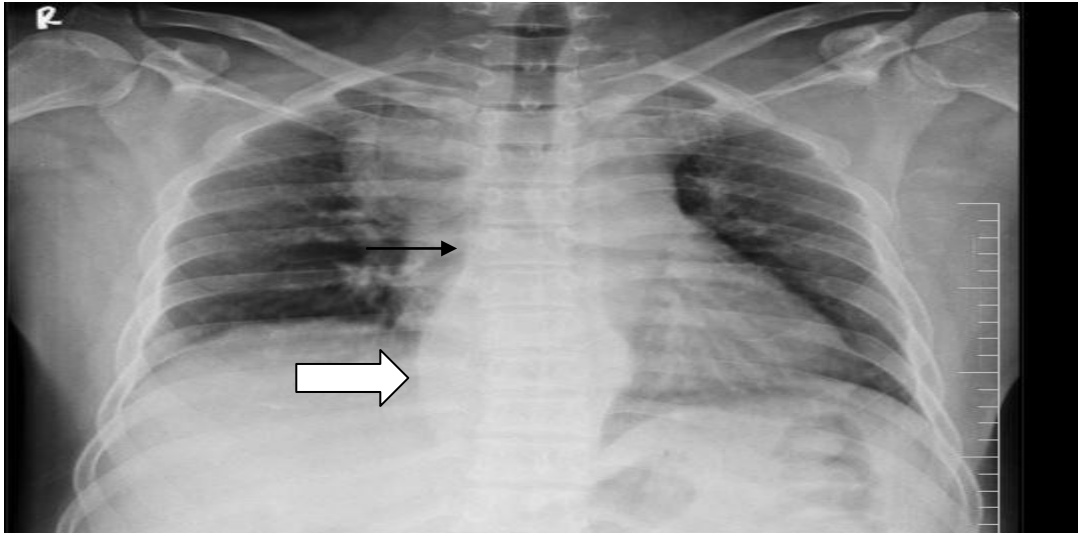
Chest X-Ray PA view of the patient
